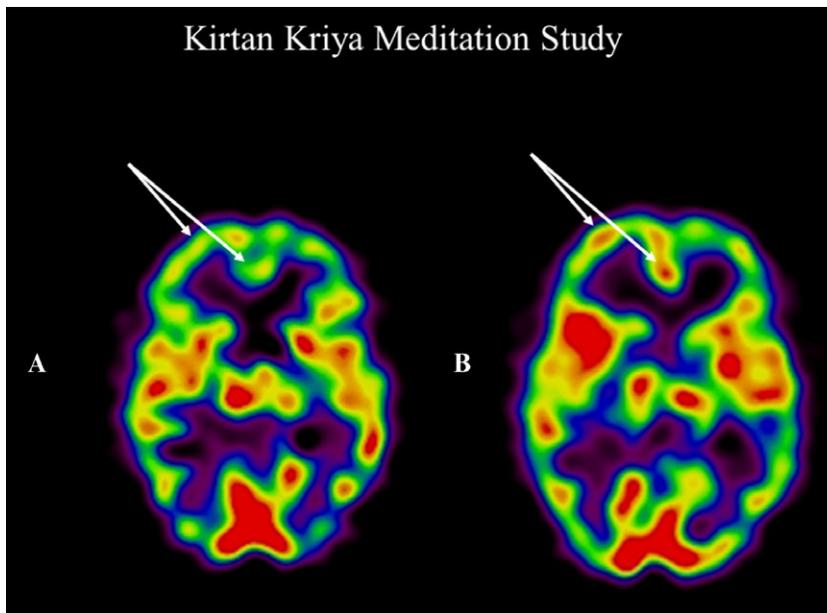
Resting SPECT scans of a subject in the Kirtan Kriya meditation study before (A) and after (B) eight weeks of daily meditation practice. The scans show increased perfusion at rest in the prefrontal cortex and anterior cingulate gyrus (arrows) after participating in the meditation program.
